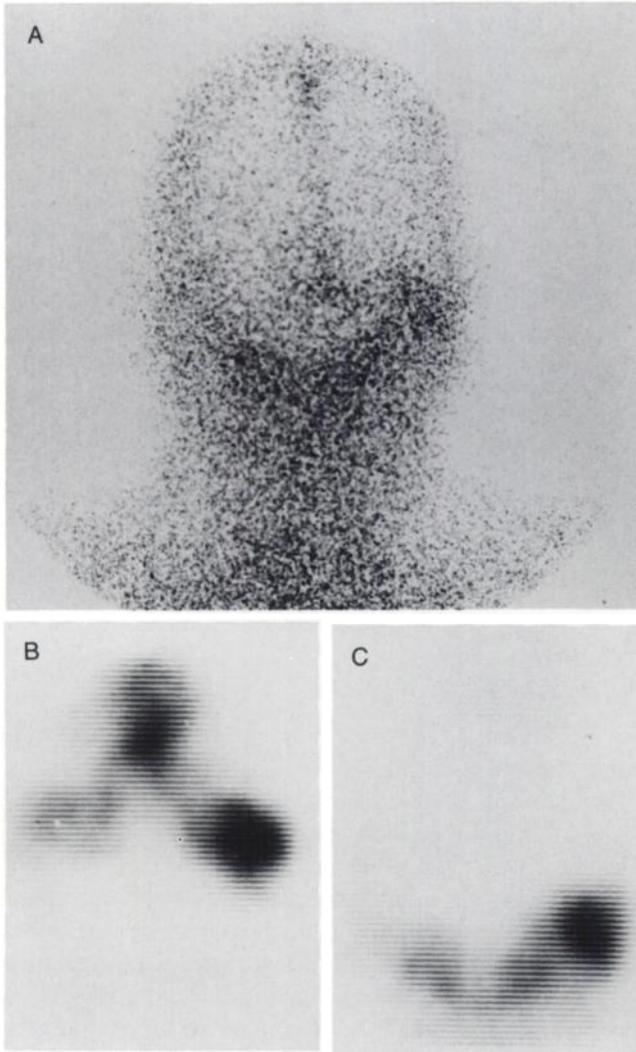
A 62-yr-old male with a 6-wk history of right facial pain and drainage from the right external auditory meatus confirmed to be mastoiditis (Patient 51). (A) Posterior skull view 48 hr after injection of ^{111}In -polyclonal IgG. Increased uptake is seen in the region of the right mastoid. (B) Transaxial SPECT view shows asymmetric activity in the mastoids. (C) Coronal SPECT view.
